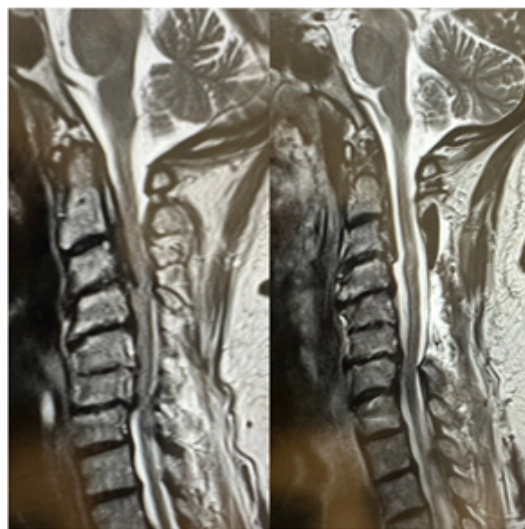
Pre and Post op MRI of a patient demonstrating adequate dural expansion and space for cord after posterior decompression. 240x240mm
